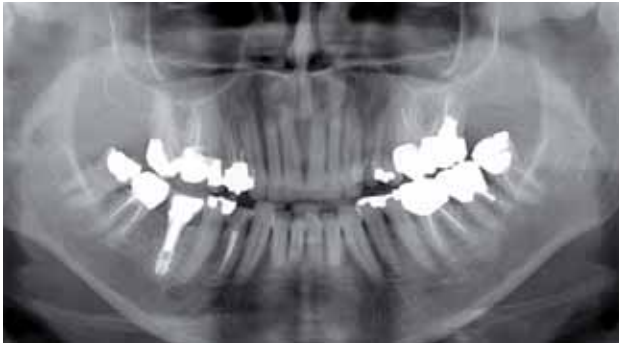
Pre-operative panoramic x-ray taken in January 2007.
